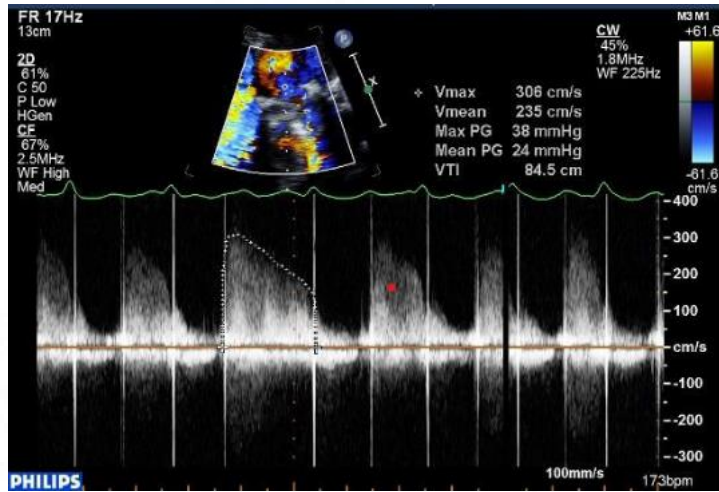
showing elevated prosthetic valve gradient on continuous wave doppler
